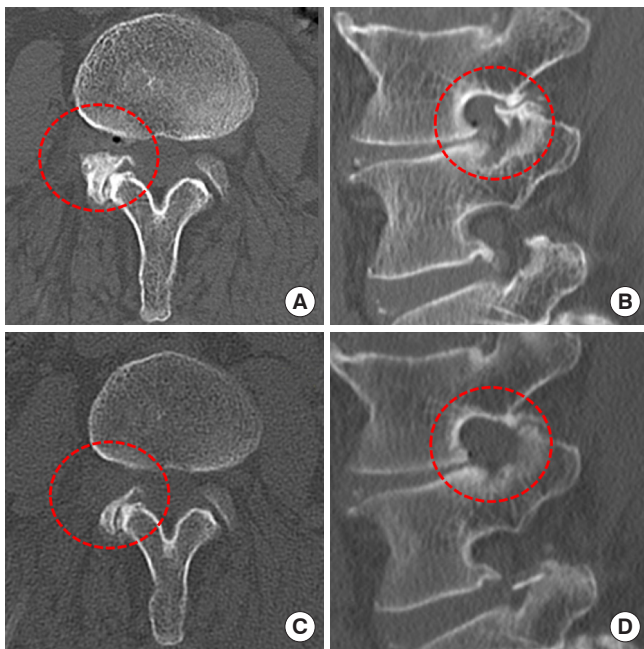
The preoperative (A, B) and the postoperative computed tomography (C, D) images of the patient in Fig. 6. The foraminal stenosis from osteophytes and disc was decompressed on both axial (C) and sagittal (D) images as seen in the area outlined in red (the target foramen).
